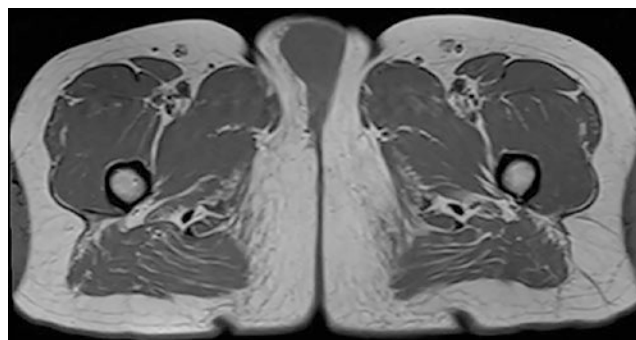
Axial T1-weighted image: on the right labia majora, there was an intermediate signal mass with a clear boundary
